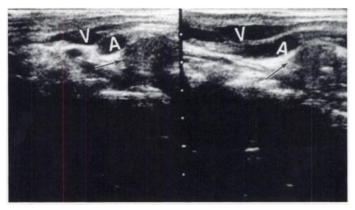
Sonograms show postoperative recurrence of thyroid carcinoma. (Left) Transverse section on left side. Just medial to the common carotid artery (A) and internal jugular vein (V) is hypoechoic mass (arrow) due to recurrent carcinoma. (Right) Longitudinal section on right side. The mass (arrow) is easily seen.
